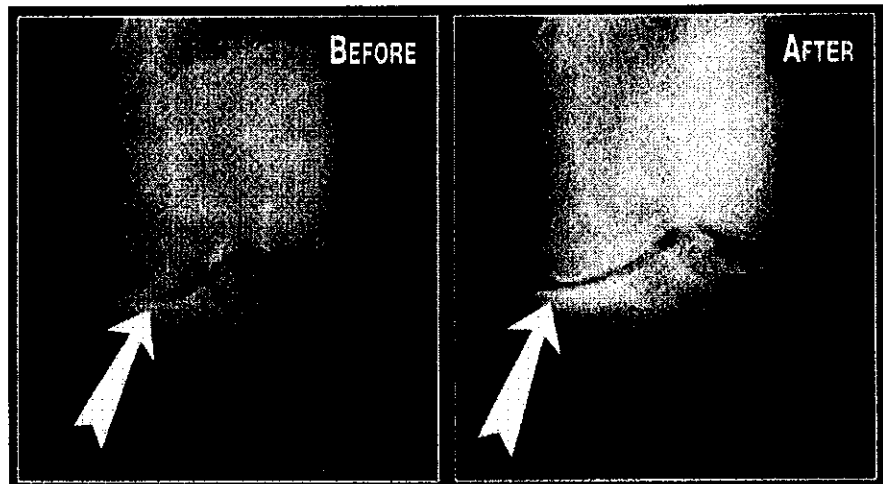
Xray before and after Prolotherapy. From Hauser, *Prolotherapy: An Alternative to Knee Surgery*, Beulah Land Press, Oak Park, IL, 2004. Used with permission.
